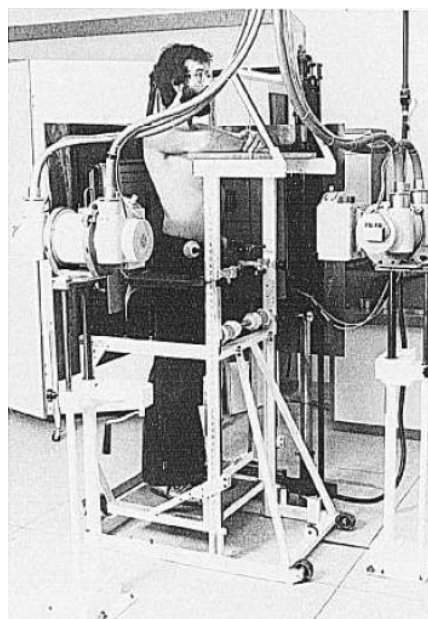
Scanning of a subject using biplanar radiography (Pearcy et al., 1985).
